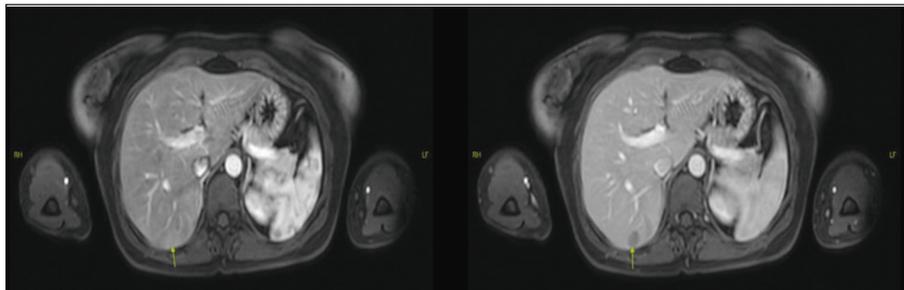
Arterial mild enhancement and venous washout on dynamic contrast-enhanced magnetic resonance imaging.
